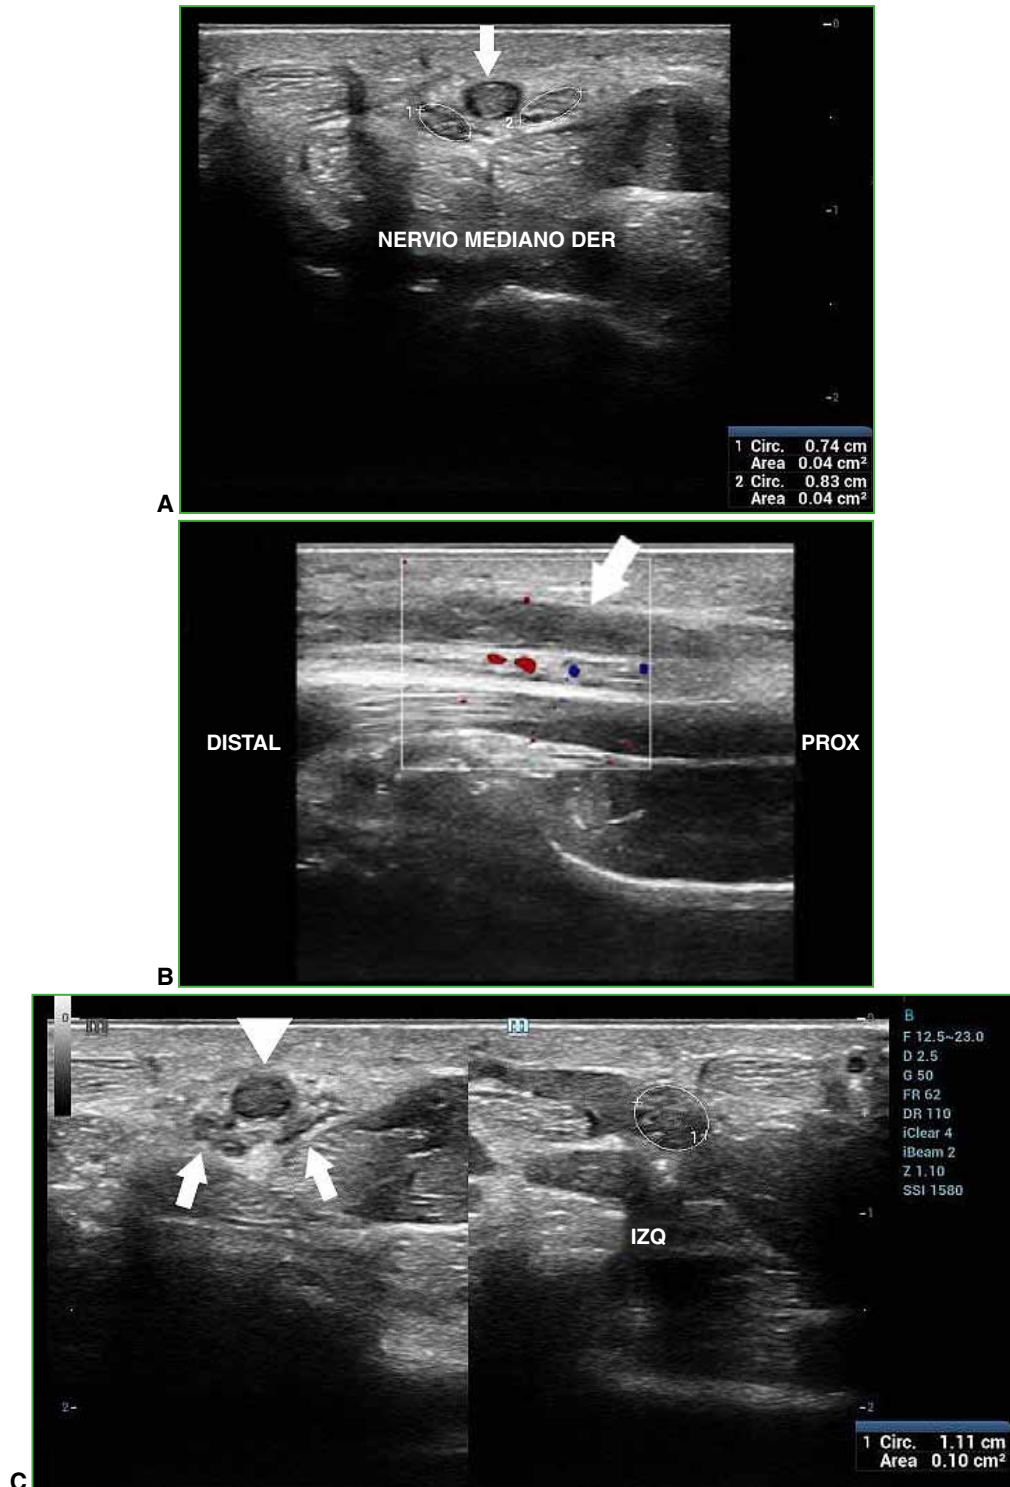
Ultrasound of the right wrist, with a high-frequency transducer. A. Cross section of the median nerve, showing its bifid morphology with a rounded tumor that separates it, with a hypoechoic signal (arrow). As a whole, the median nerve has a diameter of 8 mm². B. Longitudinal section of the wrist, showing a tubular tumor with echogenic material inside (arrow), without flow on Doppler examination. C. Cross section with comparative study of the median nerve. Right: study of the right wrist with the bifid median nerve (arrows) and the tumor in the middle (arrowhead). Left: The left median nerve is seen, with normal characteristics.
